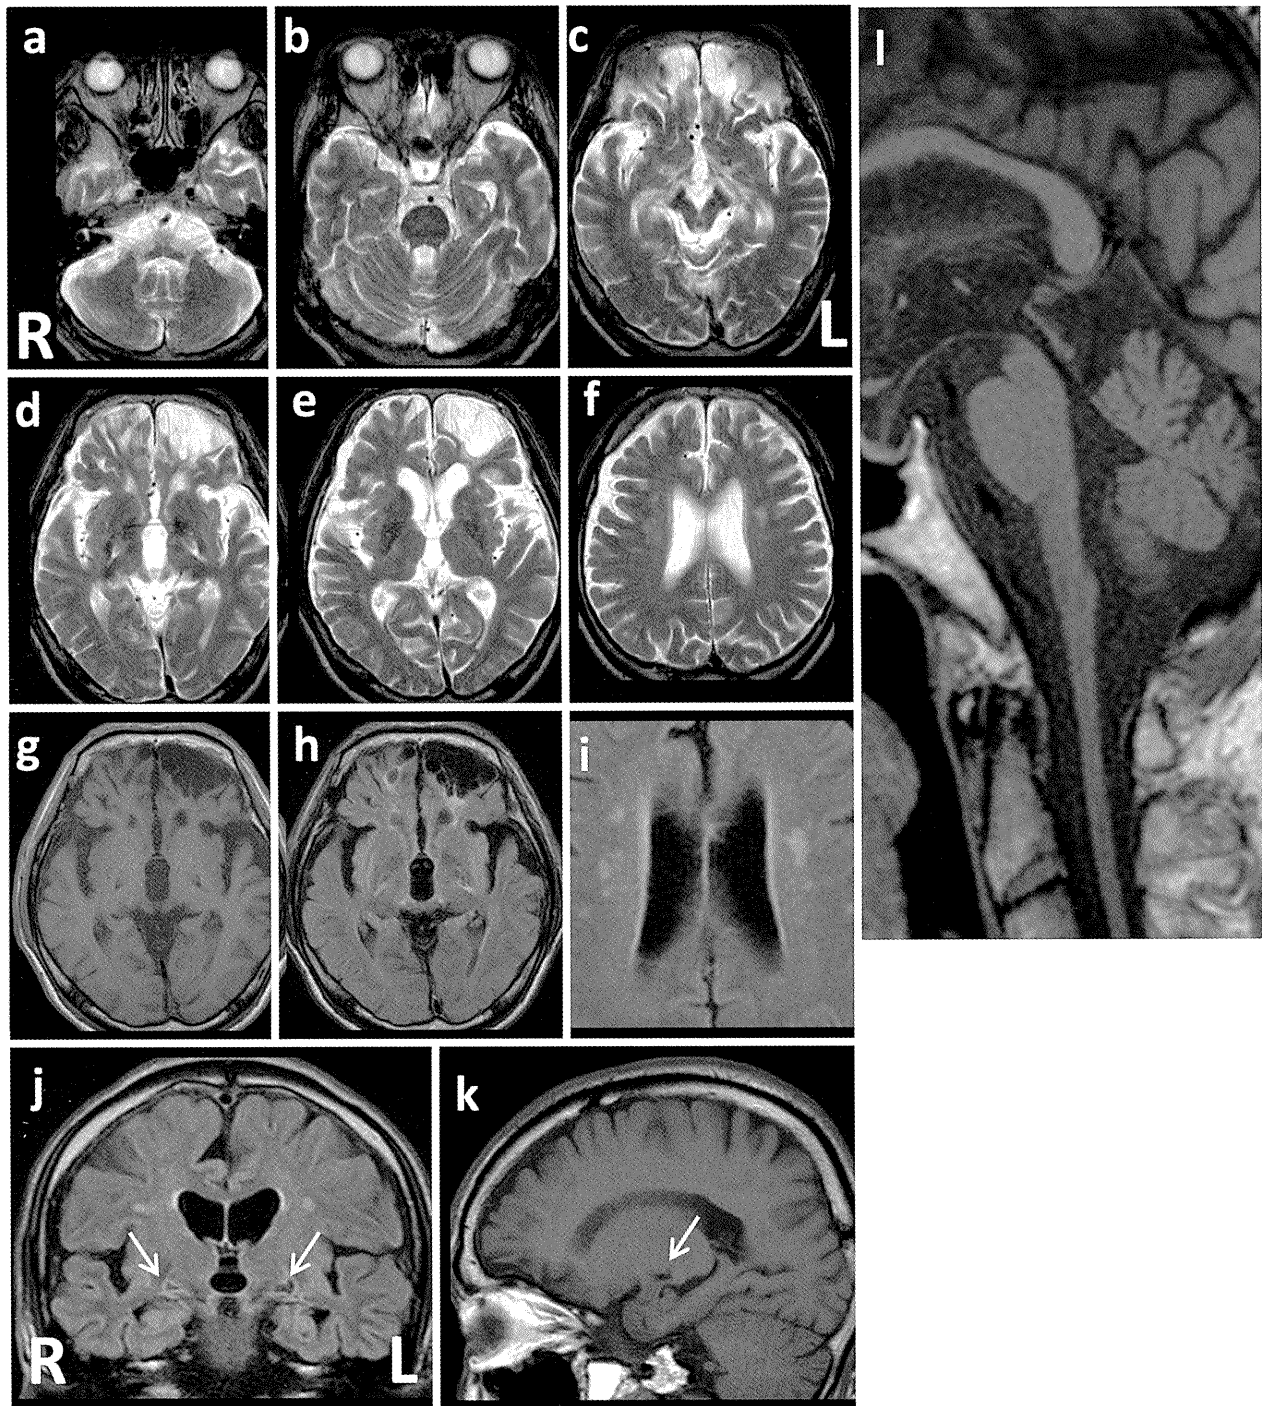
Brain MRI of a patient with adult-onset Alexander disease. a-f: T2-weighted axial images showing marked atrophy of the medulla oblongata (a) with slight cerebellar atrophy (a, b) but little atrophy of the pontine base (b), enlargement of the fourth ventricle (b), atrophy of the midbrain, especially the dorsal part (c), bilateral changes in the posterior part of globus pallidus (d), bilateral lesions of the fronto-orbital areas, predominating on the left, caused by brain contusion (d, e, g, h), moderate cortical atrophy with ventricular enlargement (e, f), and bilateral lacunae in the deep white matter, but no leukoencephalopathy (f). g and k: T1-weighted images of the lesions on axial (g) and sagittal (k) sections. h, i and j: FLAIR images of the lesions on axial (h, i) and coronal (j) sections. The lesions on coronal (j) and sagittal (k) sections are indicated by arrows. Note the absence of ventricular garlands [15]. l: T1-weighted sagittal section showing typical tadpole-like brainstem atrophy, consisting of marked cervico-medullary atrophy with an intact pontine base; note that atrophy of the midbrain tegmentum also contributes to the formation of the tadpole.
